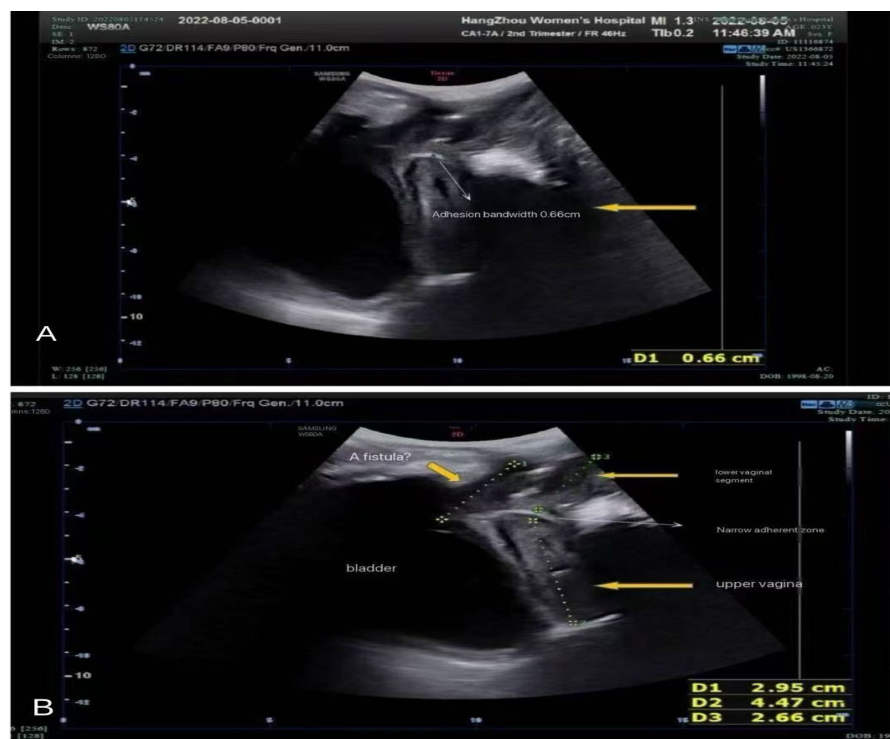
Transabdominal ultrasound.
